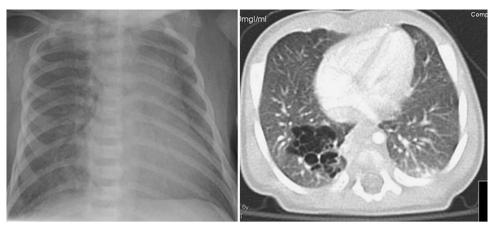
Left: X-ray image of an asymptomatic newborn with an antenatally diagnosed CCAML in the right lower lobe. Right: CT scan confirming the presence of multiple normal cysts in the right lower lobe
